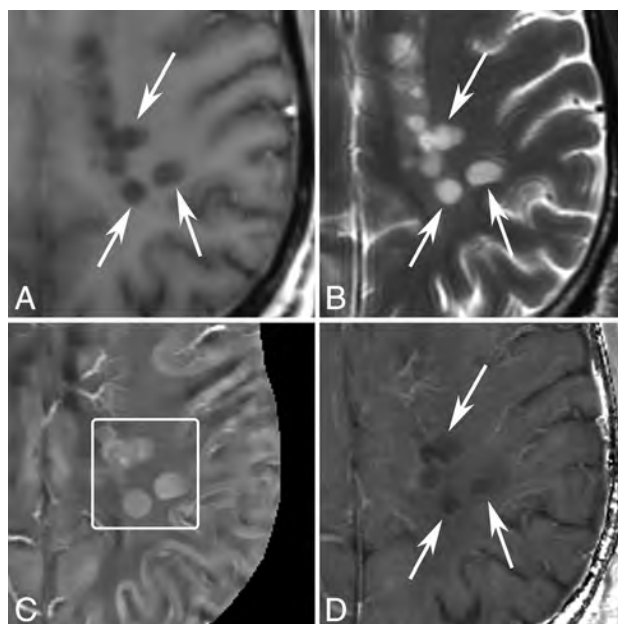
MR images of new T2 nonenhancing lesions (< 0.7 years old) in a 42-year-old man with MS. A, T1WI + Gd. B, T2WI. C, QSM. D, R2*. More than 3 new nonenhancing lesions (arrows) are found by comparing with the former MR imaging 0.7 years ago. All of them appear QSM hyperintense (C, box) and have hyperintense rims on R2*.
